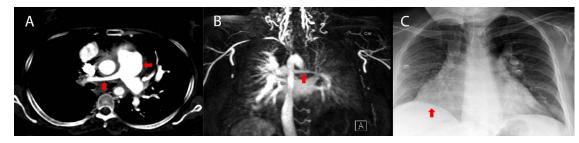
(A) Chest CT angiography with right main pulmonary artery stenosis and dilation of the pulmonary artery trunk (red arrows). (B) The right pulmonary artery branch is thinned, and the left pulmonary arterial tree alternates between areas of stenosis with posterior dilation of the main branches (red arrow). (C) Cardiomegaly with a prominent right heart profile (red arrow) (Color version of the figure is available online.)
